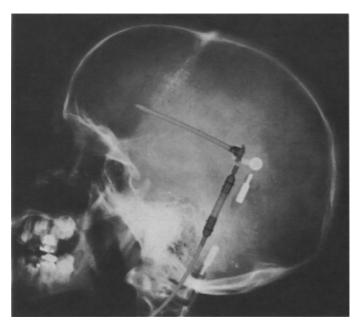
X-ray of the skull in profile with the HOLTER valve next to its excessively large X-ray image
